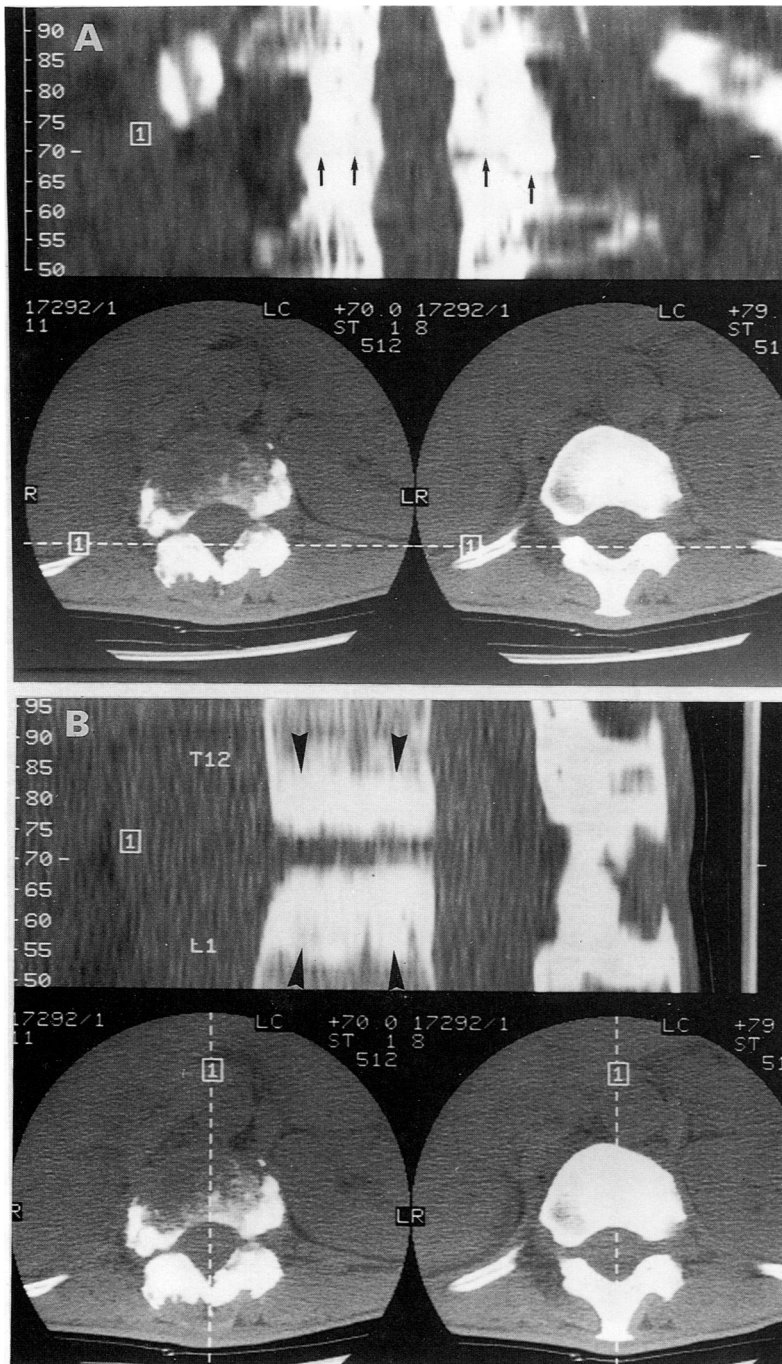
Reformatted (A) posterior coronal and (B) midline sagittal CT images show transverse linear breaks through the posterior elements bilaterally (arrows). The facet joints are fused, hypertrophied and sclerotic. Discovevertebral lesion with adjacent sclerosis is well demonstrated (arrowheads).
